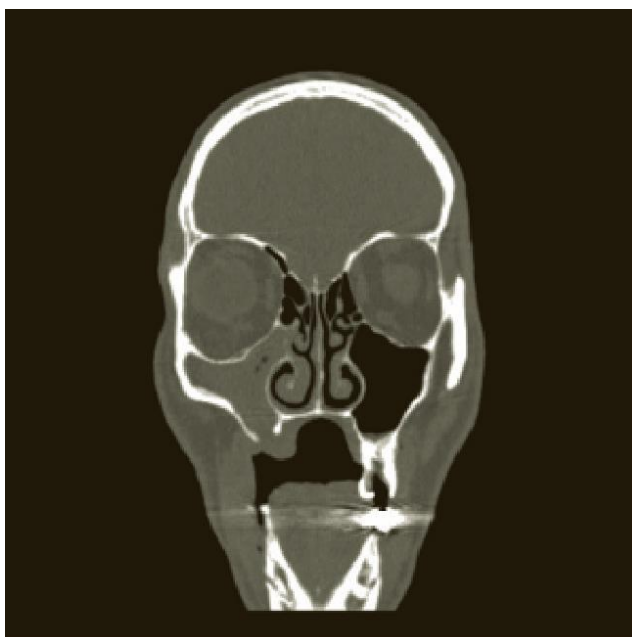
Coronal CT scan from male patient with leishmaniasis infection, showing similar bone changes to rhinomaxillary syndrome. Note: maxillary changes in leishmaniasis are often asymmetric (Jabbar et al. 2017: 252. Open Access).
